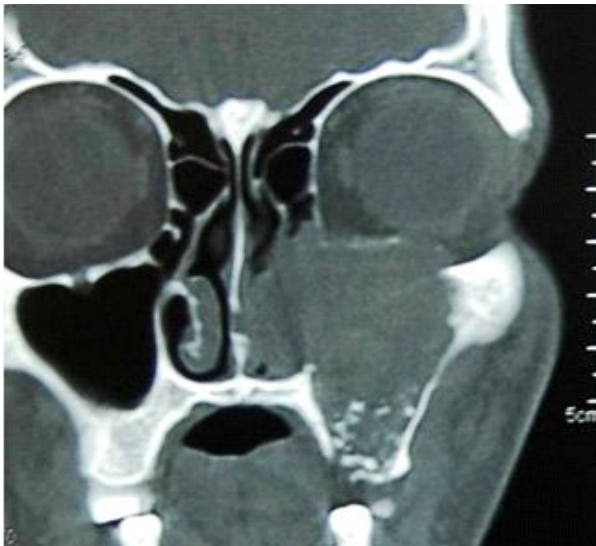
CT scan showing specks of calcifications and erosion of the floor of the maxillary sinus.
